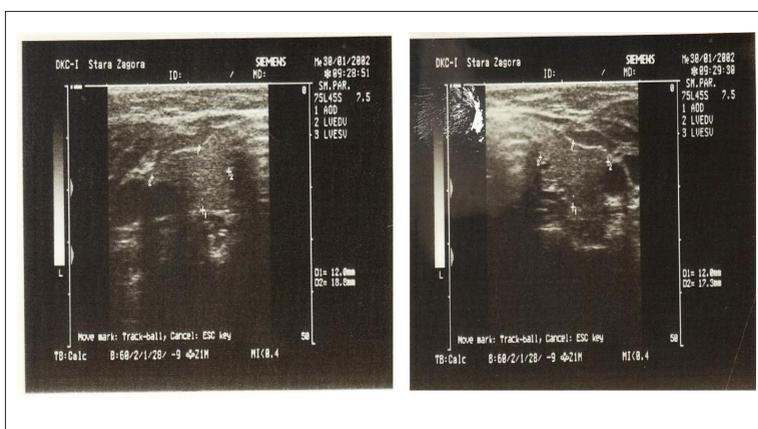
Ultrasound of thyroid gland at age 11
